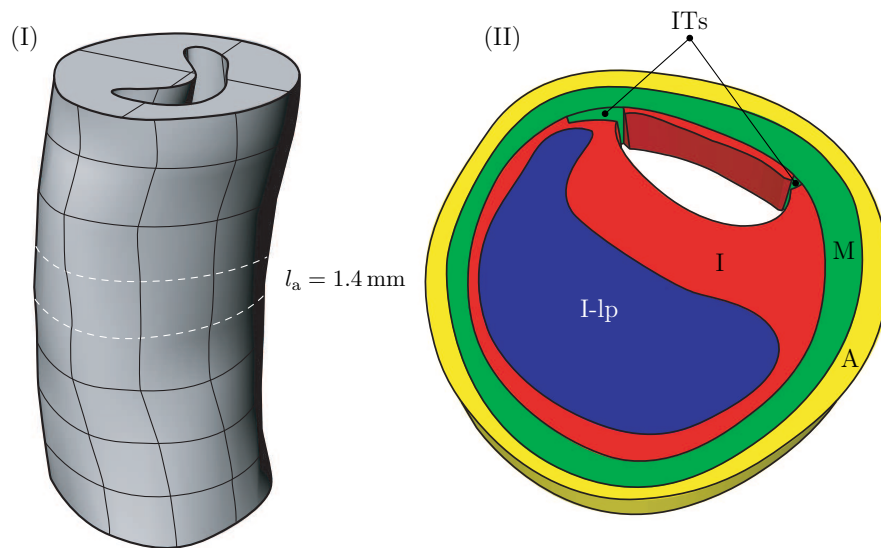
(I) 3D geometric model of a stenotic human iliac artery obtained from high-resolution MRI and reconstructed by means of NURBS. (II) Extracted arterial slice with length  $l_a = 1.4 \text{ mm}$ , composed by four arterial tissues: adventitia (A), media (M), intima (I) and lipid pool (I-lp). The introduced initial tears (ITs) are also indicated.
